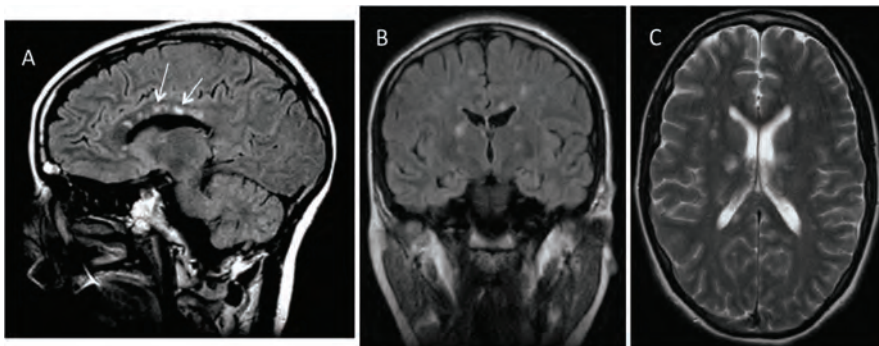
MRI brain of a patient with Susac's syndrome. (A) Sagittal fluid attenuated inversion recovery (FLAIR) sequence showing corpus callosal 'snowball' lesions (arrows) whose central location in the callosum makes them pathognomonic of Susac's syndrome. (B) Coronal FLAIR and (C) Axial T2 sequences showing focal, punctate microinfarcts in the subcortical white matter and callosum. Figure 3A has been reproduced with permission from Elsevier.⁹
